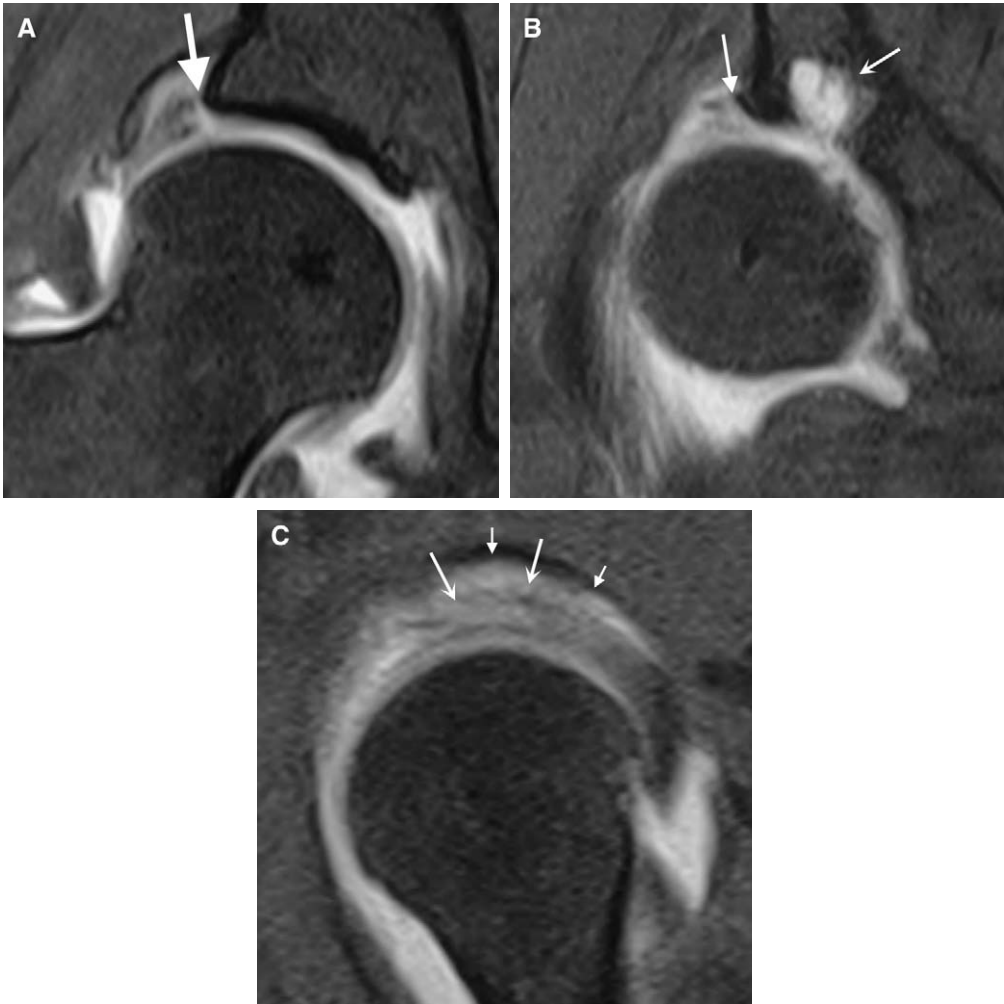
Fat-suppressed T1-weighted images with intra-articular gadolinium from a patient with developmental dysplasia of the hip. Coronal images from posterior to anterior (*A* and *B*) reveal a labral detachment (*arrows with straight heads*). The labrum is likely degenerative with irregular margins and diffuse intermediate signal. A large subchondral cyst is present (*B*, *arrow with curved head*). Note the disruption of the articular cartilage and subchondral bone at the base of the cyst. On the sagittal image (*C*) the labral detachment is visible (*short arrows*). An intrasubstance tear (*long arrows*) is also seen with significant distortion of the anterior aspect of the labral (on the left). The tear and detachment involve the anterior and superior labrum.
